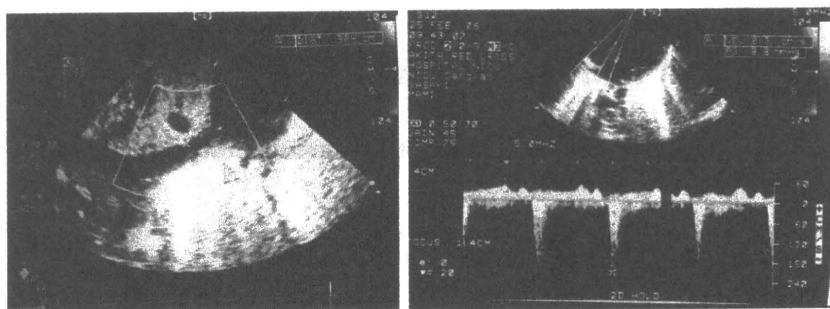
Infant echocardiography. Echocardiography showed dilated inferior vena cava (left) and tricuspid regurgitation (right) at day 0.
